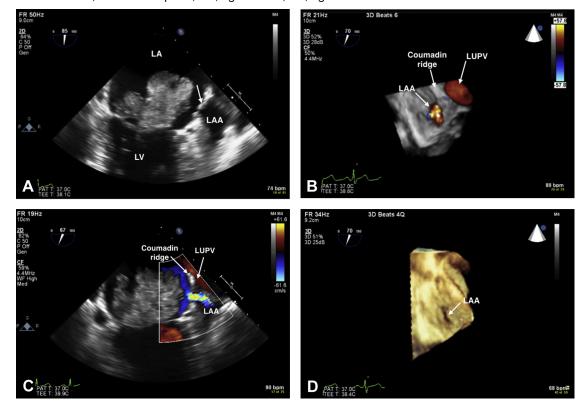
(A) Midesophageal two-chamber view focused on the left atrial appendage (LAA) and mitral valve. The myxoma is seen in close proximity with the LAA. A partially occluding membrane (*arrow*) is seen at the opening of the LAA in the left atrium (LA). (B) Threedimensional data set with color flow Doppler showing en-face the opening of the LAA with turbulent blood flow. (C) Midesophageal mitral commissural view focused on the LAA and mitral valve. (D) Three-dimensional en-face view showing a very narrow opening of the LAA. *LUPV*, Left upper pulmonary vein; *LV*, left ventricle.
